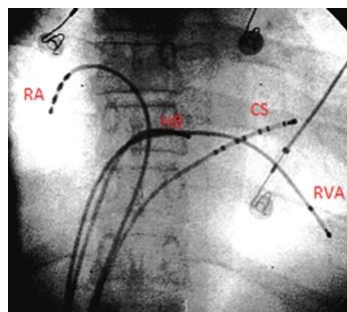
projection radiographs showing different catheters using in electrophysiological tests in patient with AP. (CS: coronary sinus; HB: His bundle; RA: Right atrium; RVA: right ventricle apex.)
